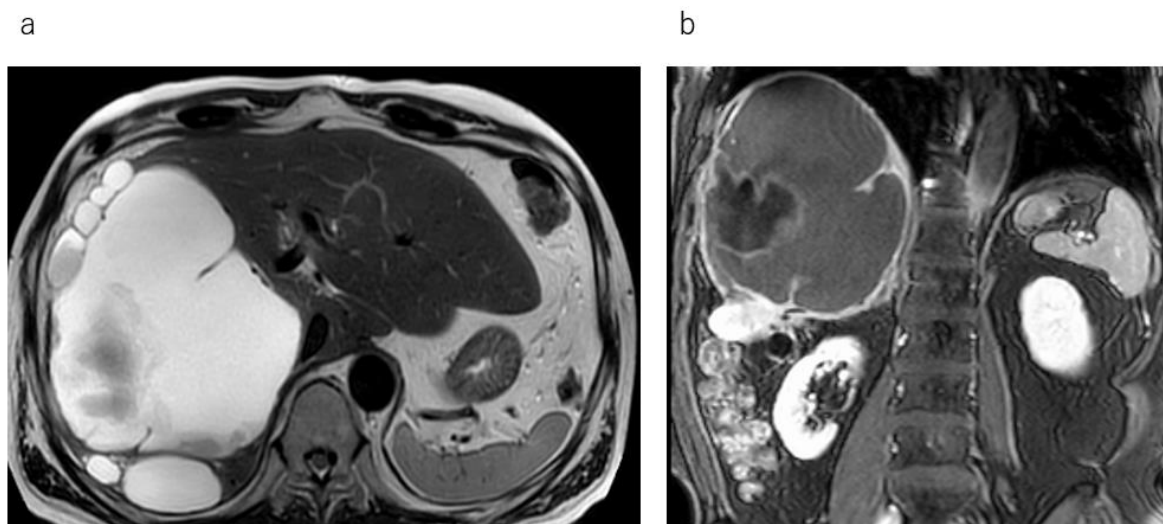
(a, b) MRI results. There were no signs of possible cystadenoma or cystadenocarcinoma.
